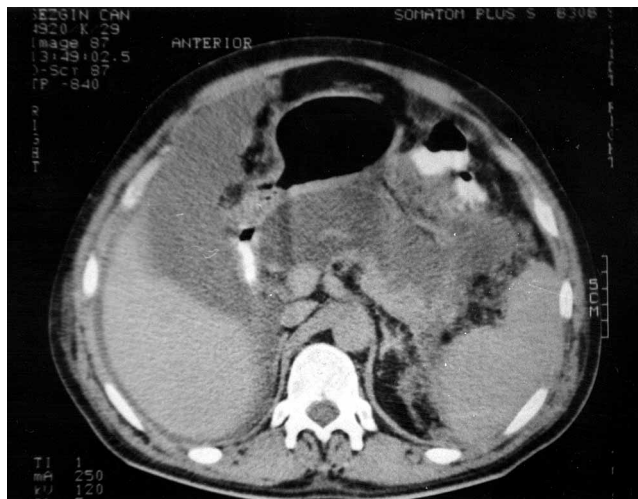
CT shows diffuse necrosis of pancreas and omentum plus a perihepatic fluid collection.
